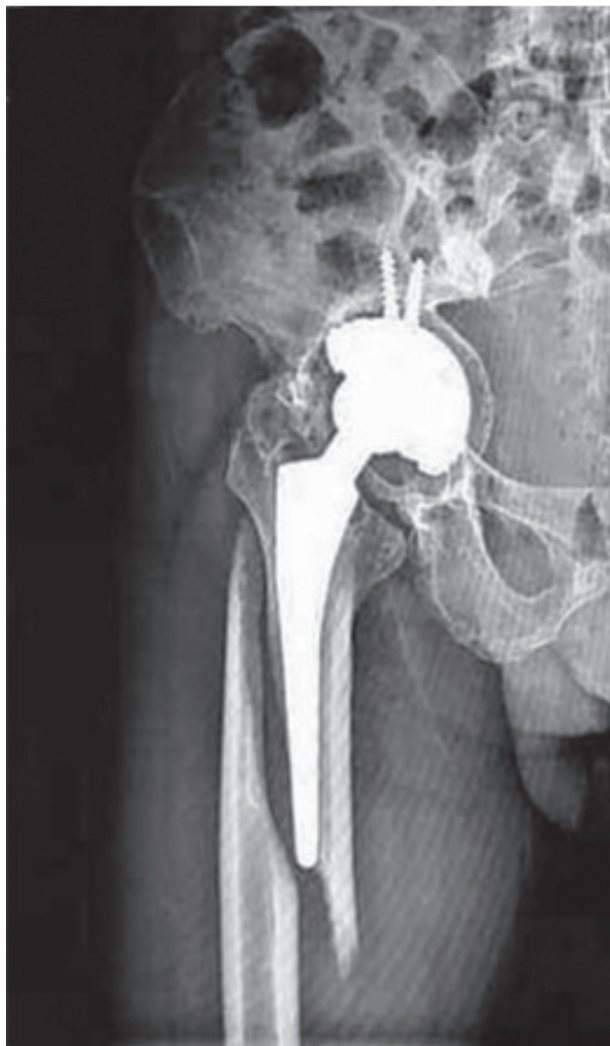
Anteroposterior radiograph of the right hip and proximal femur showing a type E periprosthetic fracture of the proximal femur with an associated fracture of the acetabulum.
